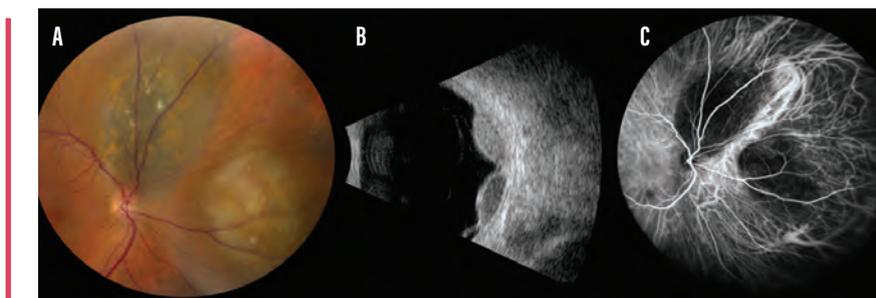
Multifocal choroidal melanoma in the right eye of a 56-year-old woman (A). B-scan ultrasonography showed two distinct hollow, dome-shaped lesions with subretinal fluid (B). Evaluation with indocyanine green angiography documented hypocyanescence at the two tumor sites with normal choroidal flow in between, implying two distinct tumors (C).
